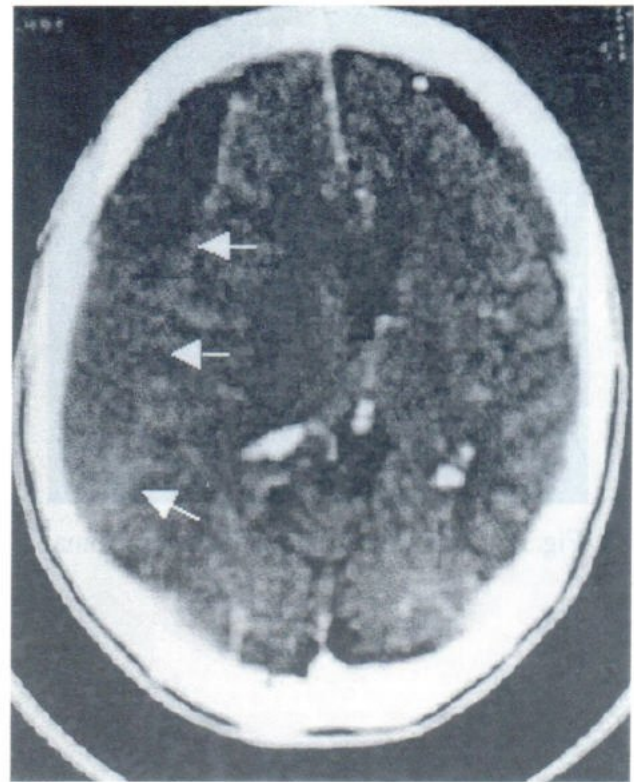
B Contrast Enhancement CT of the same patient.
